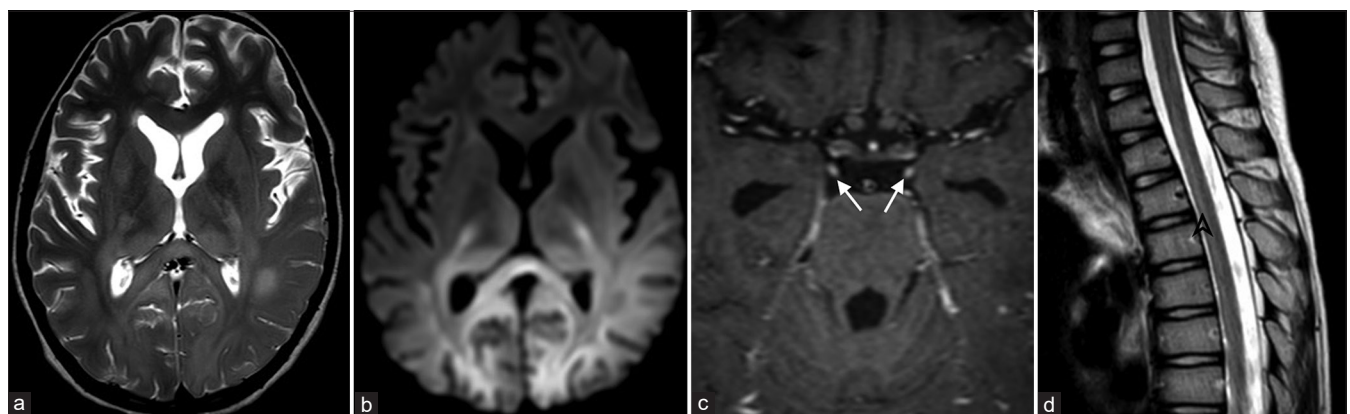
New-onset progressive dystonia and altered sensorium. Follow-up MRI brain shows: (a) Abnormal T2 hyperintense signal in bilateral parieto-occipital white matter, thalami, posterior limb of internal capsule, and corpus callosum, (b) restricted diffusion in the involved brain parenchyma, (c) post contrast 3DT1 images show enhancement along the cisternal segments of 3rd cranial nerves (arrows), and (d) intramedullary T2 hyperintensity in anterior part of dorsal cord [arrow head].
